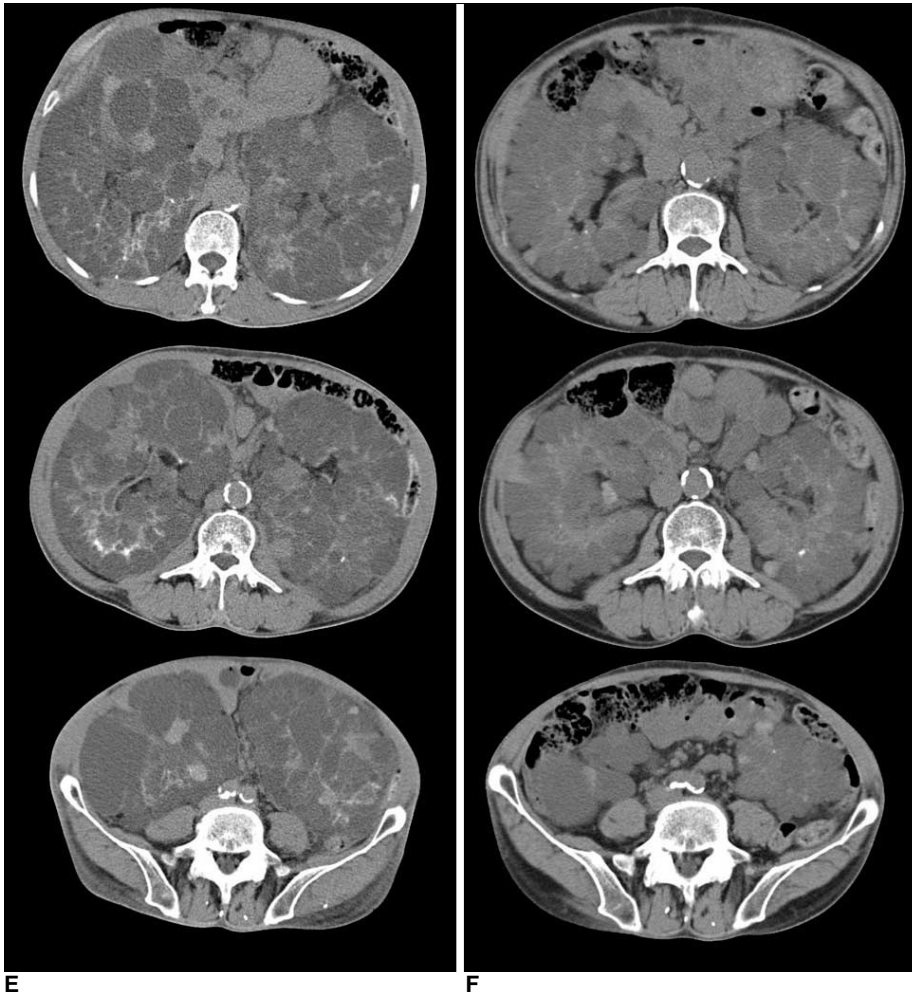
Ethanol embolization in 65-year-old man with polycystic kidneys. E, F. Changes in CT images before transcatheter arterial embolization and at 18 months after transcatheter arterial embolization show marked decrease in volume of both kidneys. G. Changes in volume of kidneys, and clinical parameters as function of time after transcatheter arterial embolization.
